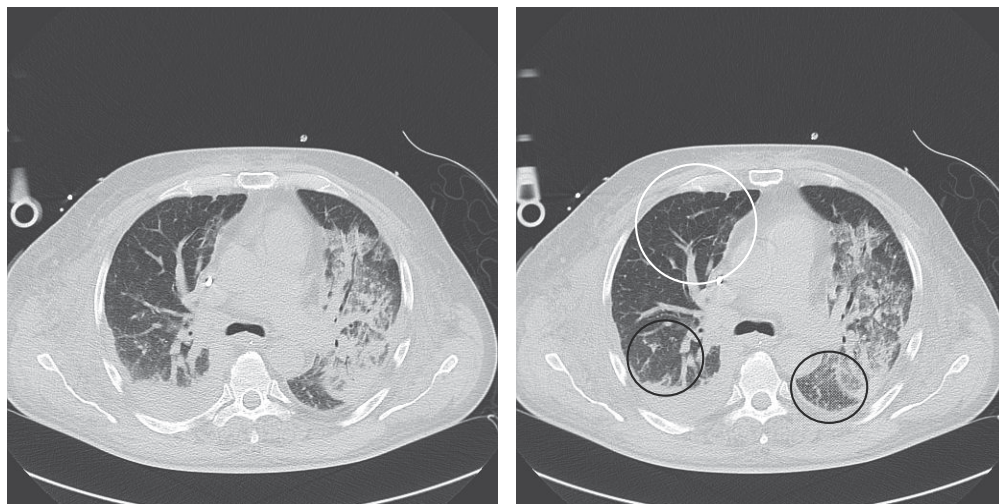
CT images of a patient under mechanical ventilation at two different PEEP levels. Left: PEEP=5 cmH₂O; Right: PEEP=15 cmH₂O. Pneumonic infiltrates in the left lung and intrapleural fluid accumulation are discernible. Lung aeration is increased, e.g. in the anterior region of the right lung (white circle) and dependent lung regions are recruited (black circles) at the higher PEEP level.
